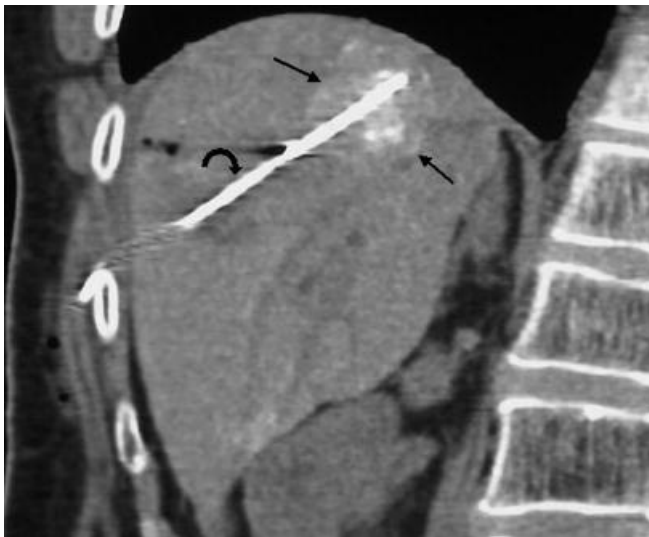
Procedure of CT-guided placement of Lumatron light device (study 2)
